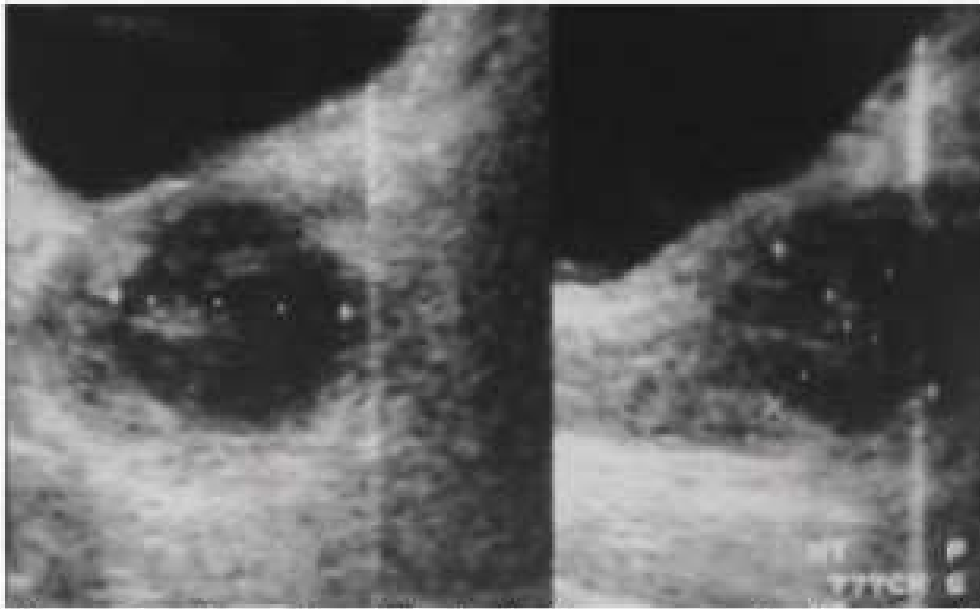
Prostatic abdominal ultrasonography showing the prostatic abscess.
